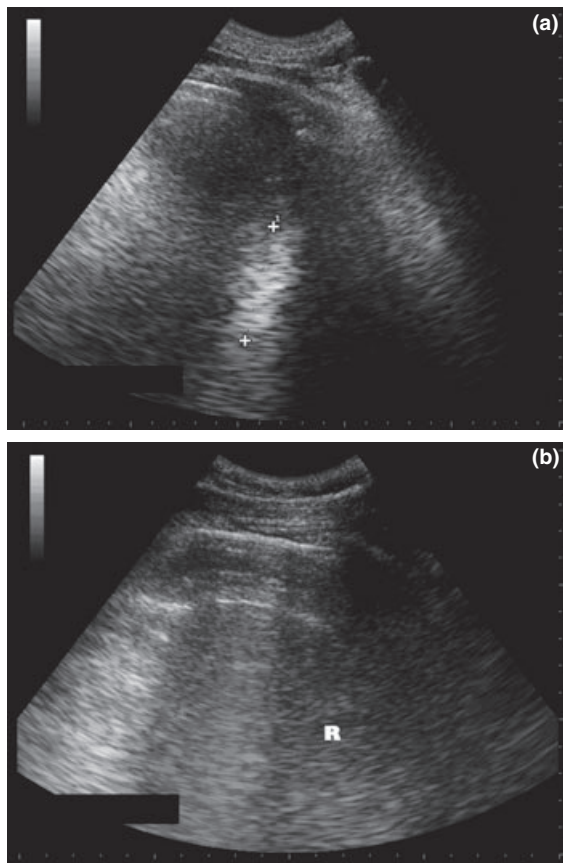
(a) Ultrasound scan showing lung consolidation before recruitment (+...+). (b) The same acoustic window as in A, but following a recruitment manoeuvre. R = residual area of alveolar consolidation.
